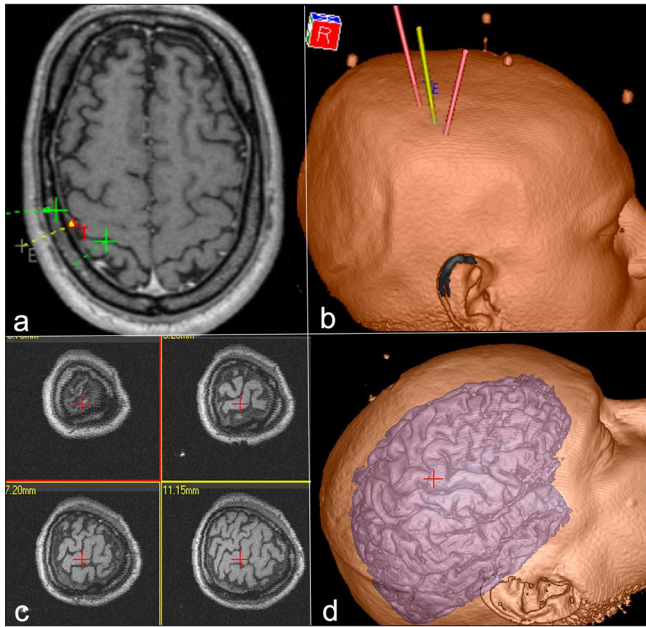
(a) Axial magnetic resonance imaging (MRI) highlighting the motor cortex (red) and the central sulcus (green) to identify the target site for motor cortex stimulation; (b) 3D reconstruction of the patient's skull showing the central sulcus projection; (c) Multiplanar views of MRI slices centered on the stimulation site; (d) 3D cortical surface reconstruction emphasizing the operative target for motor cortex stimulation in upper limb pain treatment.
